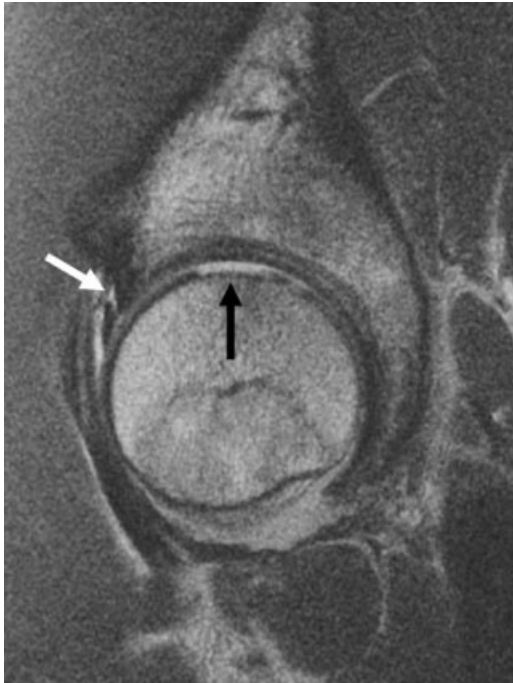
Sagittal MR image of a 19-year-old man 2 days after a posterior subluxation demonstrates a large chondral shear (black arrow) and an adjacent anterior labral tear (white arrow). Note the presence of the low signal tidemark and subchondral plate, indicative of a chondral shear as opposed to an osteochondral fracture.
